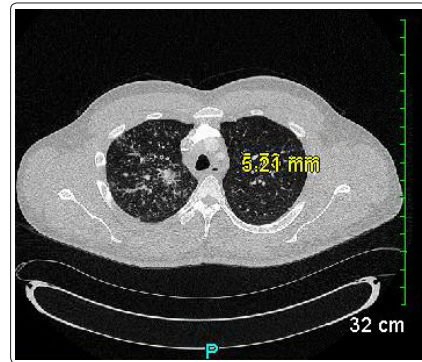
CT of Chest without Contrast
